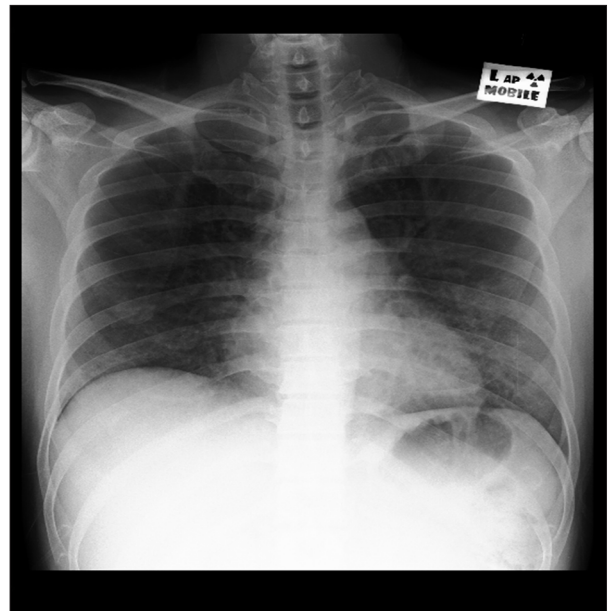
Chest X-Ray on August 4, 2020, showed lung improvement after 4 weeks of treatment
